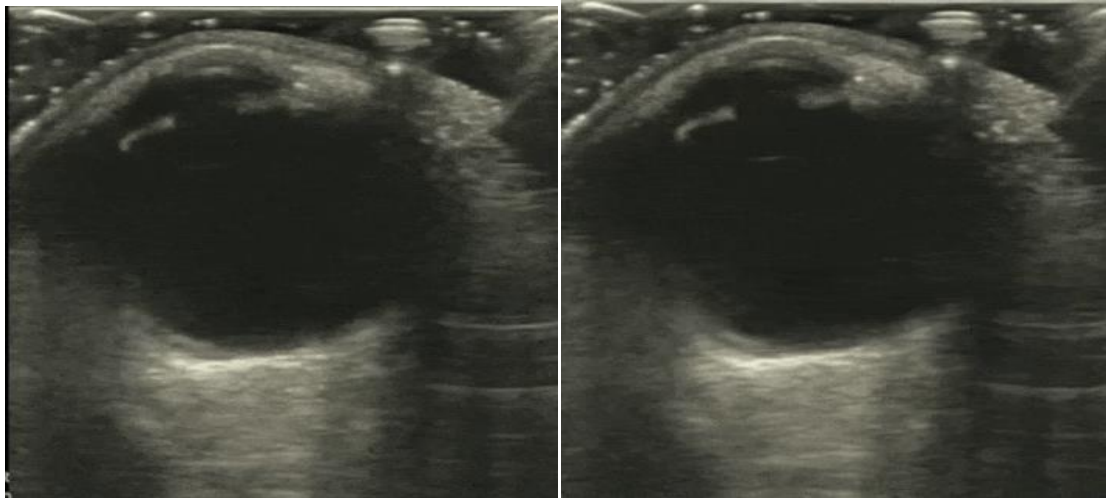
Extraocular Ocular Movement on Ultrasound (8)
